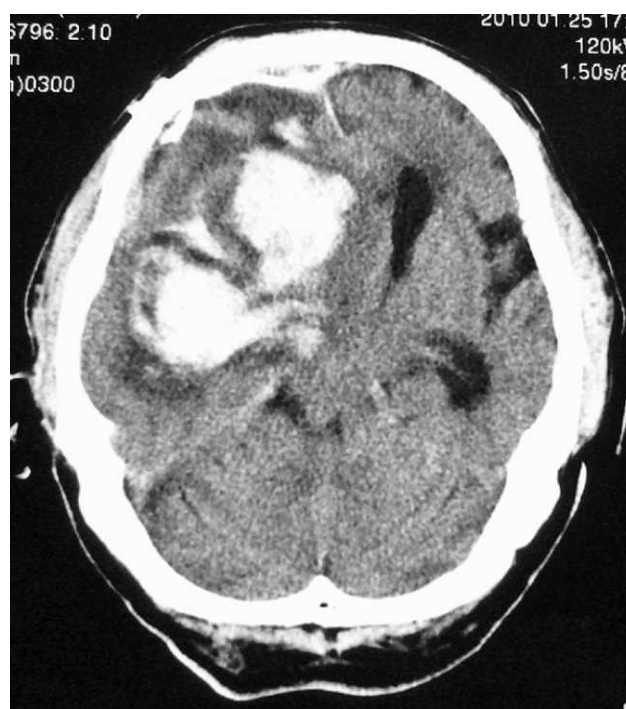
Head CT showing a recurrence of a cerebral hematoma in the right temporal lobe.
